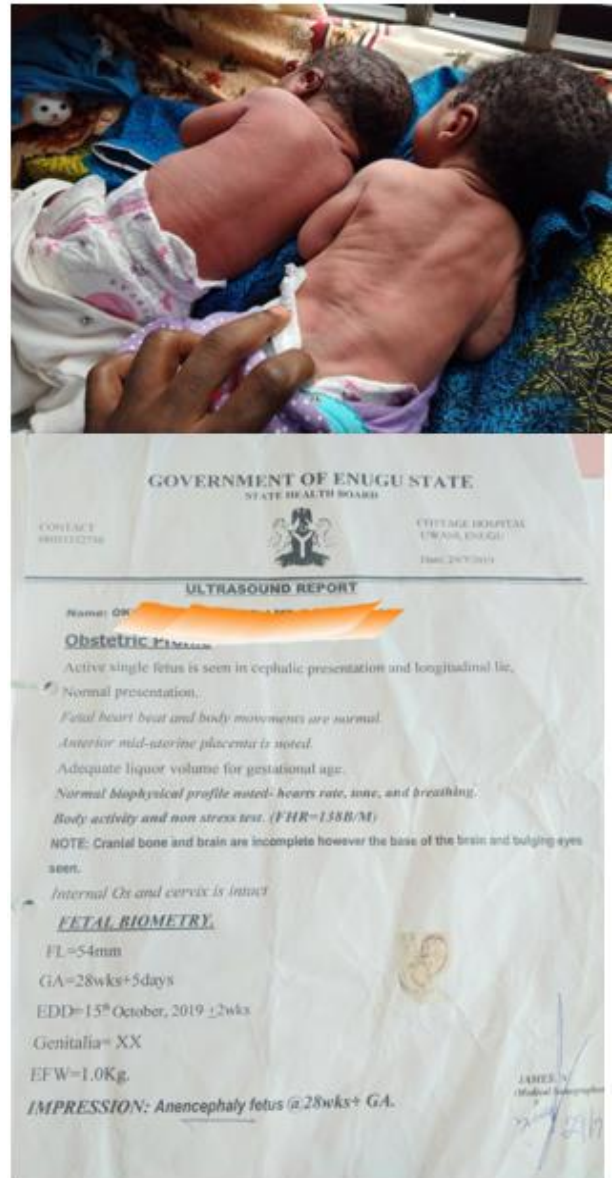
Ultrasound report.
